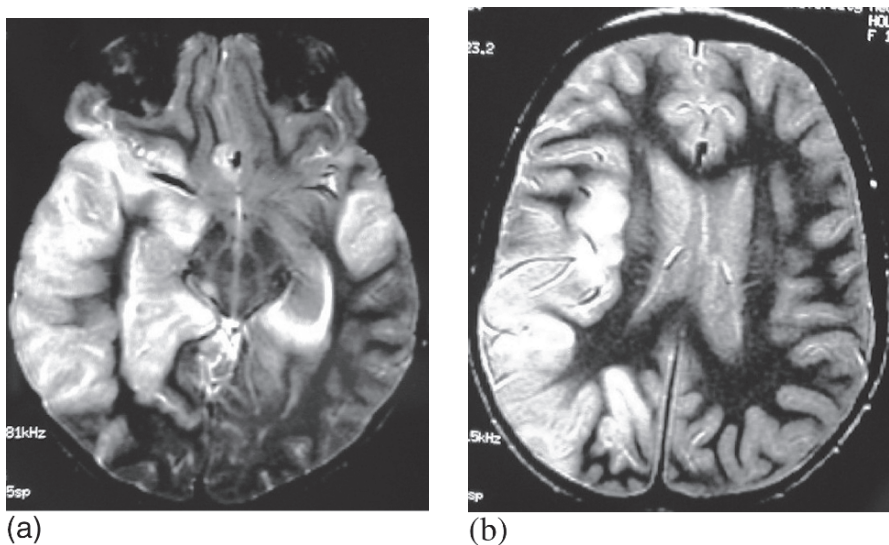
Head MRI scan, T2-weighted axial images, of a 9-year-old girl with sporadic HSV encephalitis demonstrates temporal lobe inflammation (a) and parietooccipital lobe inflammation (b), both with mass effect.
